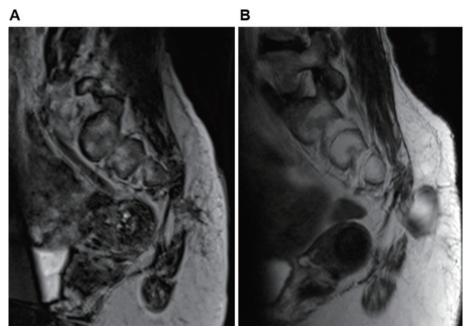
A: Lumbosacral magnetic resonance imaging (MRI) T2-weighted sagittal image after the first surgery. The meningocele was completely resected. B: Sagittal lumbosacral MRI T2-weighted image 2 years after the first surgery showing recurrence of the meningocele protruding from the sacral spine.
